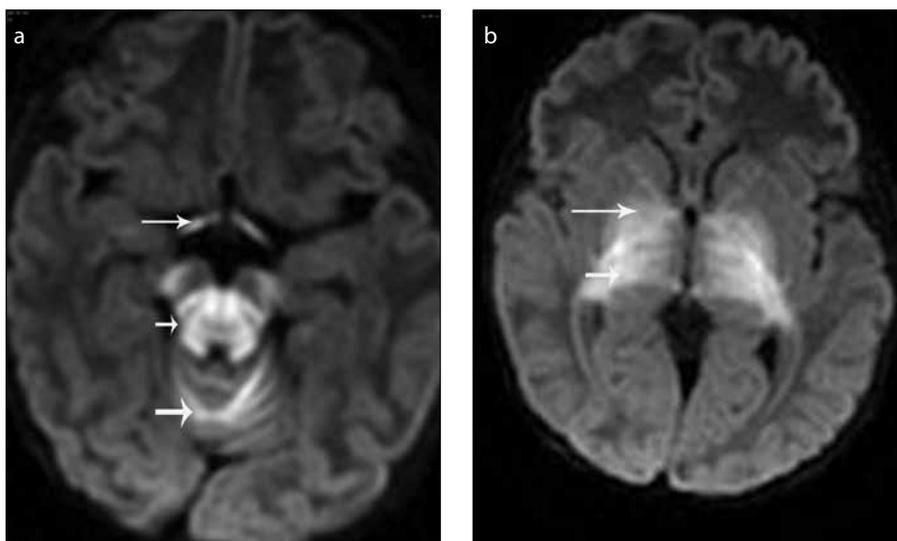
a, b. A 20-day-old boy with MSUD (patient 6). Axial DWI image (a) shows abnormally high signal intensity in the bilateral optic tract (*long arrow*), mesencephalon (*short arrow*), cerebellar vermis (*broad arrow*). Axial DWI image (b) shows abnormally high signal intensity in the basal ganglia (*long arrow*) and thalamus (*short arrow*).
